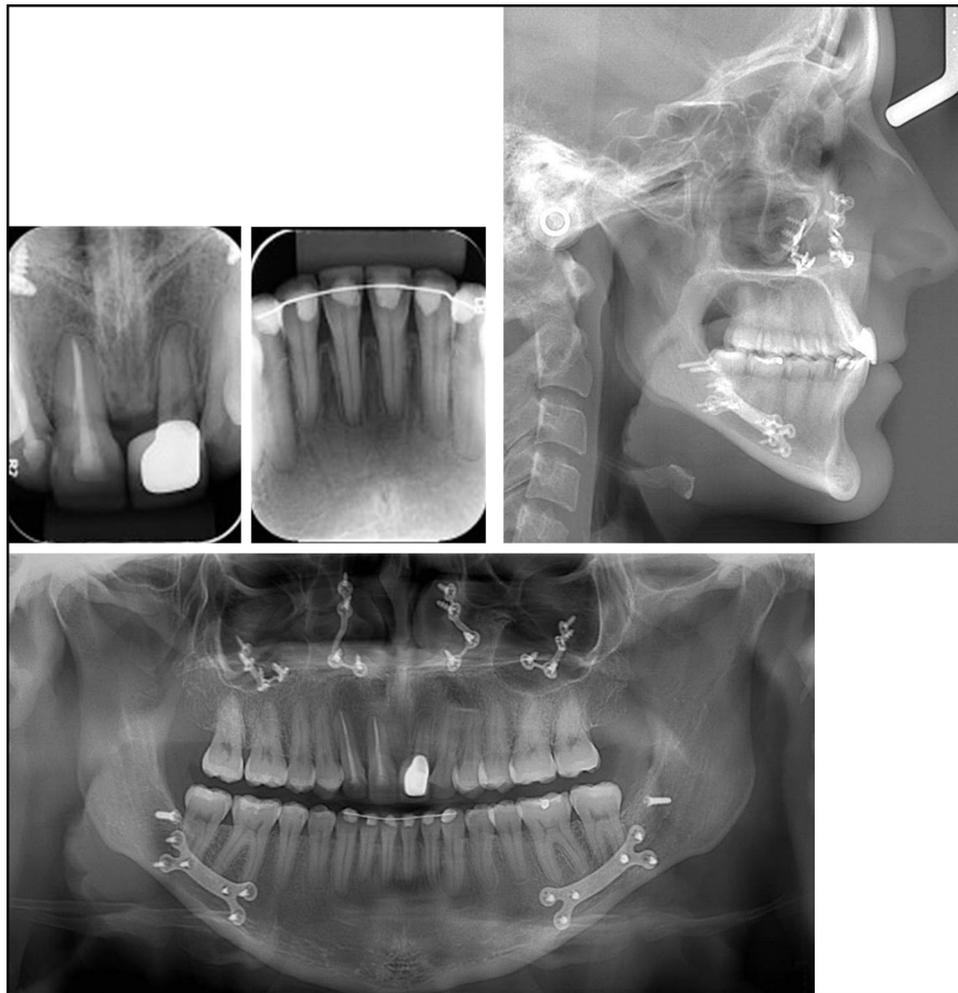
One-year posttreatment radiographs.
